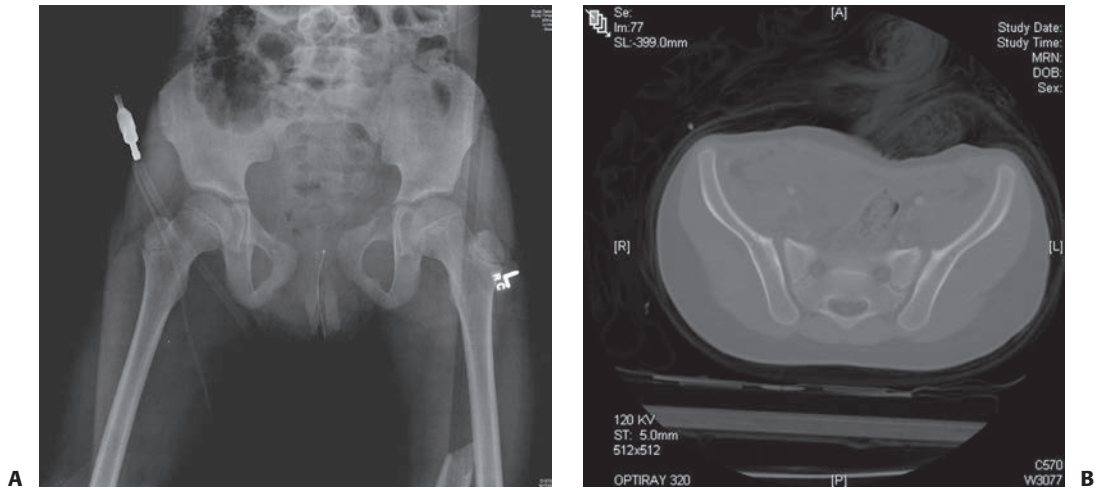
A: Fracture adjacent to the symphysis pubis with symphysis pubis separation. B: CT scan showing no posterior instability.
